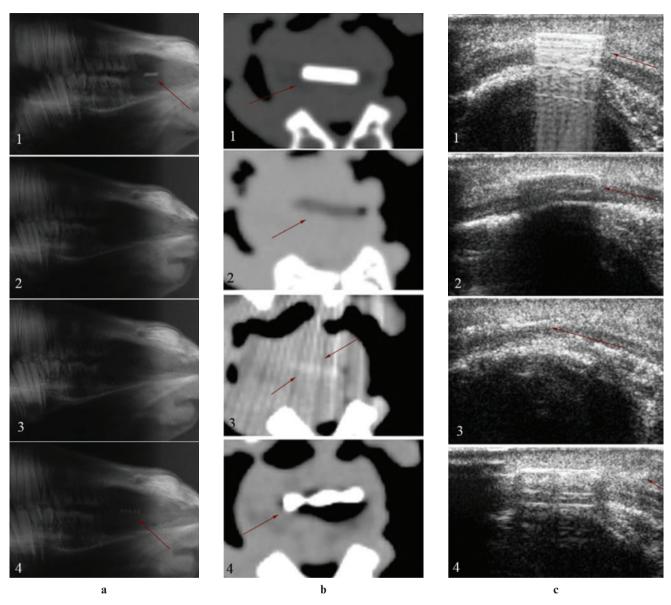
Visibility of foreign body in muscle. (a) Conventional plain radiography. (b) CT. (c) Ultrasonography. 1, glass; 2, dry wood; 3, acrylic; 4, graphite
